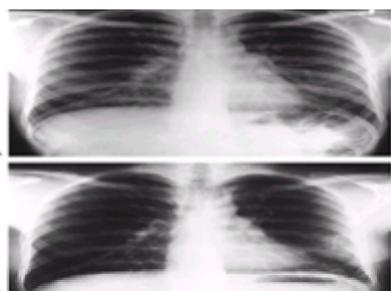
A: Chest radiograph of a patient with pigeon breeder's disease having symptoms of fever, dyspnea, and bibasilar rales. The patient had kept pigeons for 5 years and was seen with fever, dyspnea, and myalgias approximately 8 hours after cleaning the pigeon coop. He had serum antibody to pigeon dropping extract. Note 2- to 3-mm nodules bilaterally in lower lobes. B: Chest radiograph of the same patient 2 weeks later. No specific treatment was given. Note clearing of the lower lobe nodules and the staples in the left chest from the open lung biopsy.
